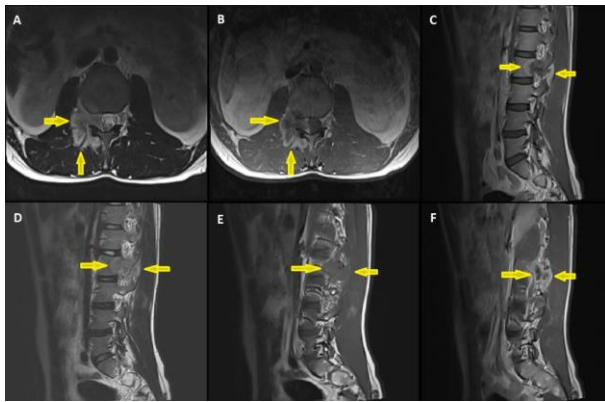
Lesion seen on preoperative contrast-enhanced lumbar MRI (Yellow Arrow).
